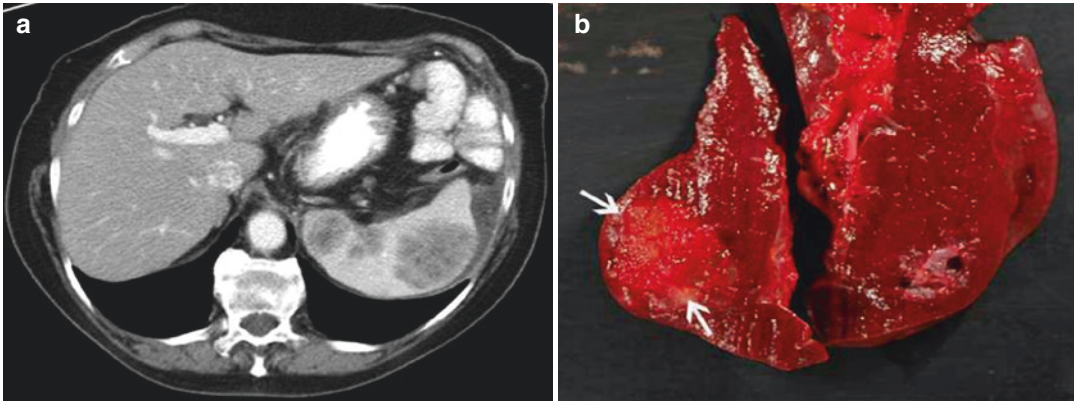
Secondary splenic malignancy: Splenic metastasis from colon cancer. (a) CT scan, (b) macroscopic appearance
